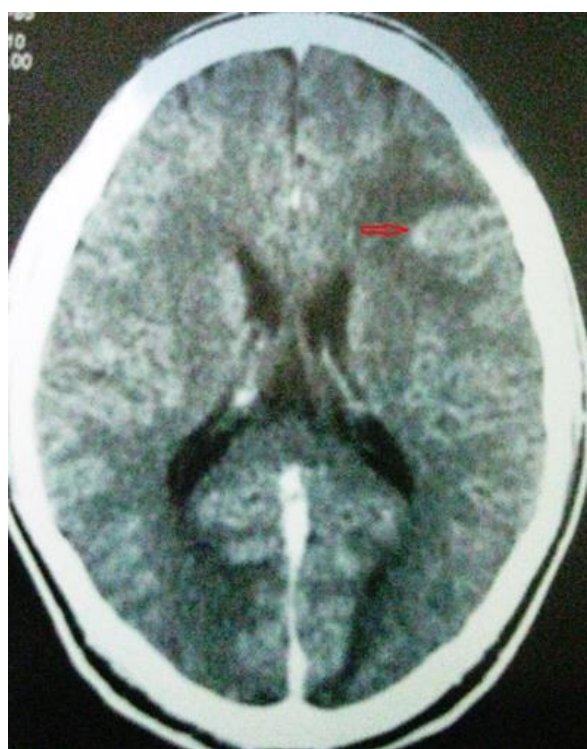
Brain exploratory CT revealed lesions in the right occipital lobe, right inner capsule, left and right parietal lobe
